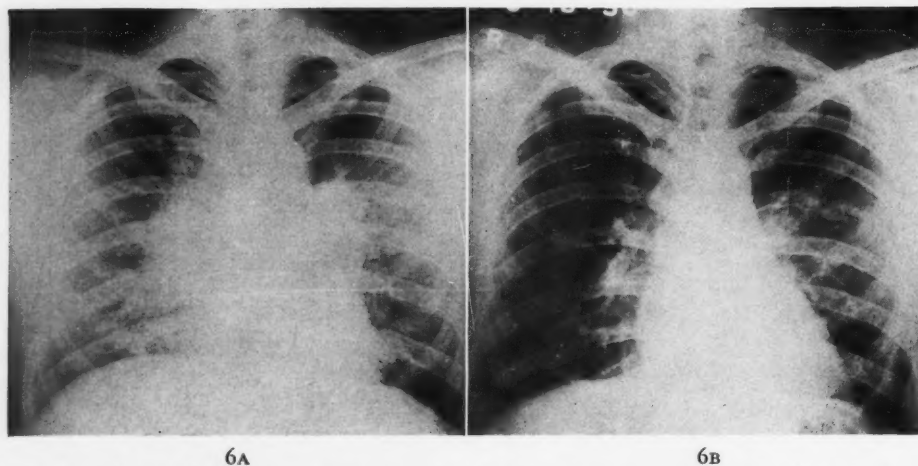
A, X-ray of the chest showing massive hilar lymph node enlargement with some fan-shaped infiltrations into both mid-lung fields; B, eleven months later there has been complete resolution.
